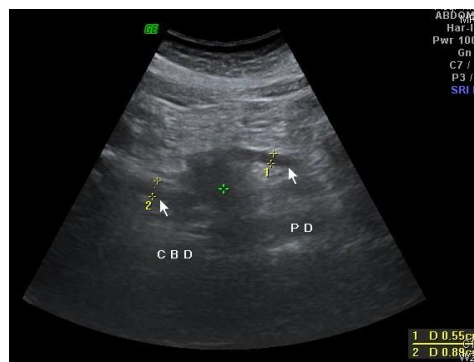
Ultrasound image shows hypochoic mass (*) at pancreatic head with dilated PD and CBD
